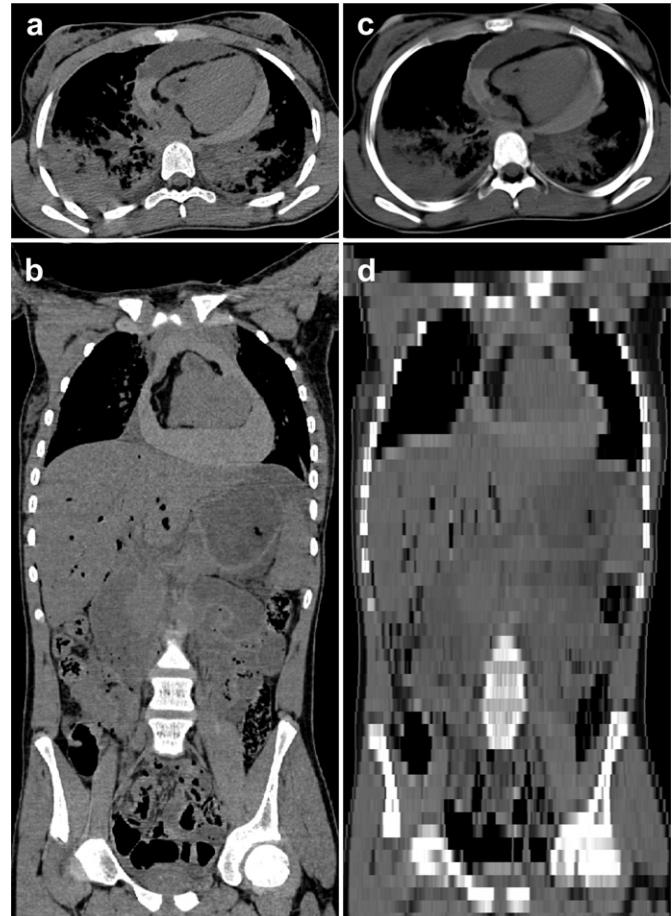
Standard CT dataset with axial (a) and coronal (b) views on the left, downsampled dataset with axial (c) and coronal (d) views on the right. Since the resampling is only performed in direction of the slices, the main loss of quality is visible in the coronal view. The appearance of the axial cuts is slightly altered, but the effusion can still clearly be seen and easily segmented. The number of slices in which the segmentation is performed is significantly decreased, therefore saving considerable time.
